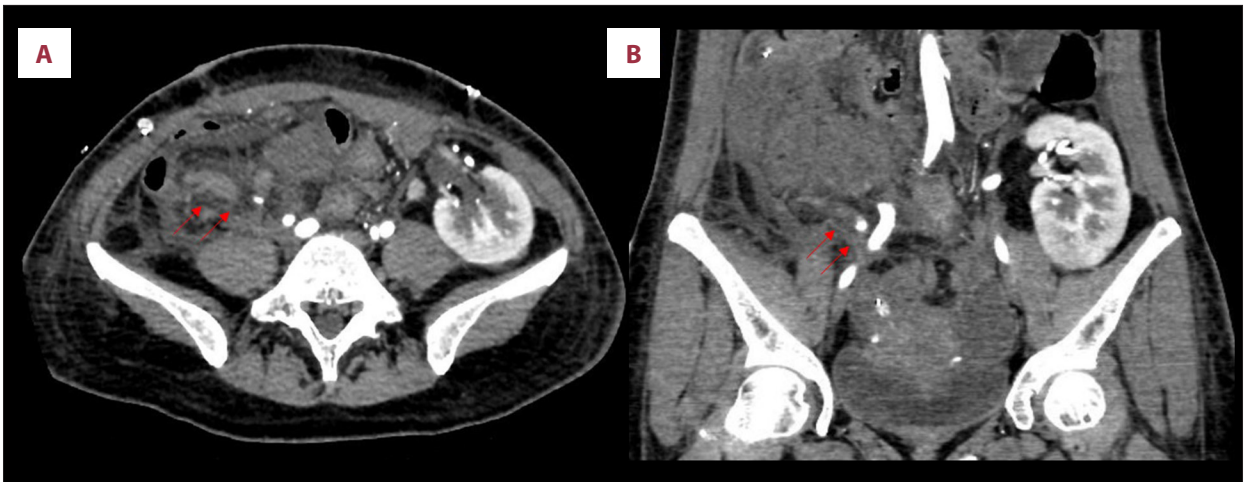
Computed tomography angiography acquired on posttransplant day 7 shows thrombosis. The splenic artery (red arrows) of the grafted pancreas showed a contrast defect along the total length. (A) Coronal view; (B) sagittal view.
